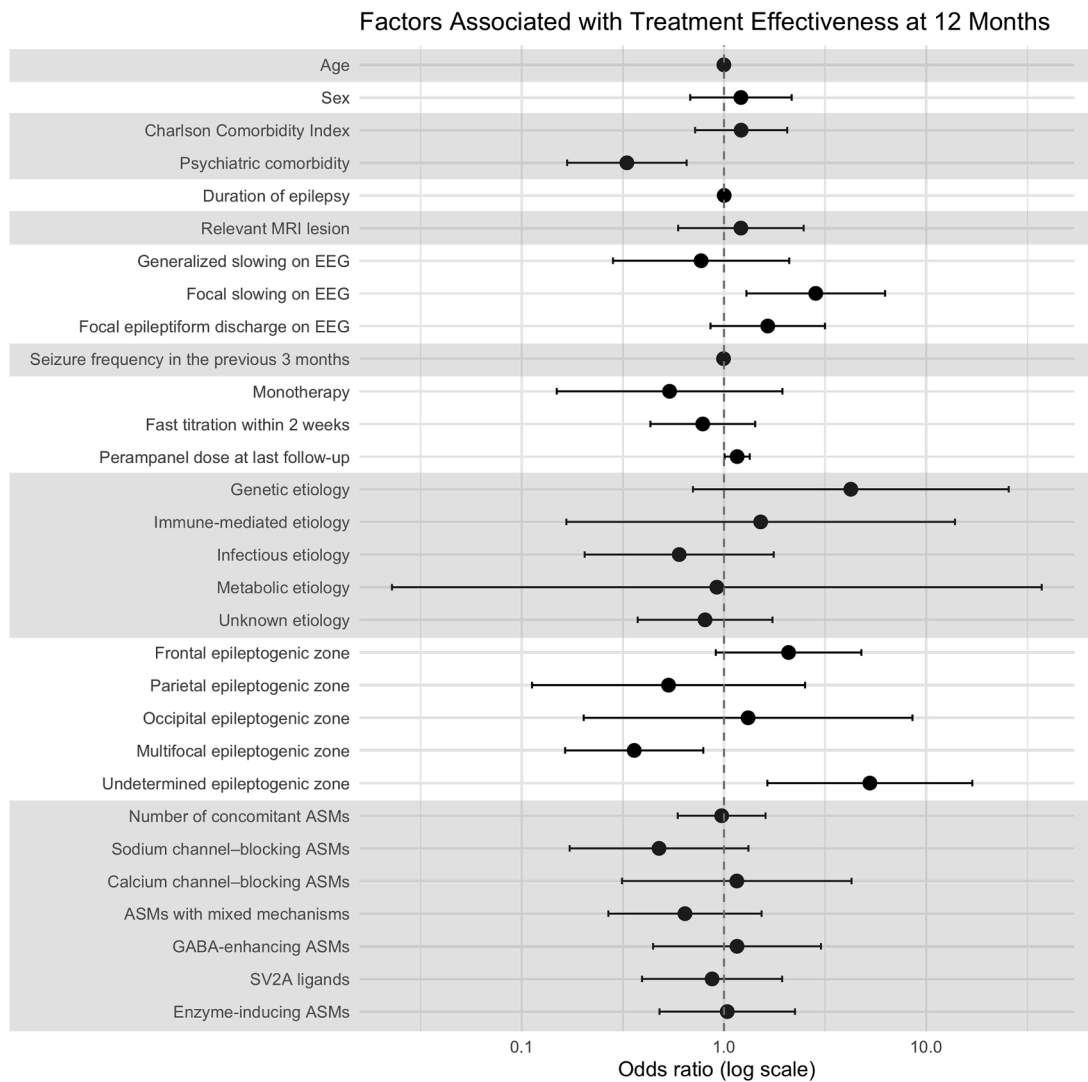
Factors associated with treatment effectiveness at 12 months identified by multivariate logistic regression analysis. ASM, antiseizure medication; EEG, electroencephalography; MRI, magnetic resonance imaging.
